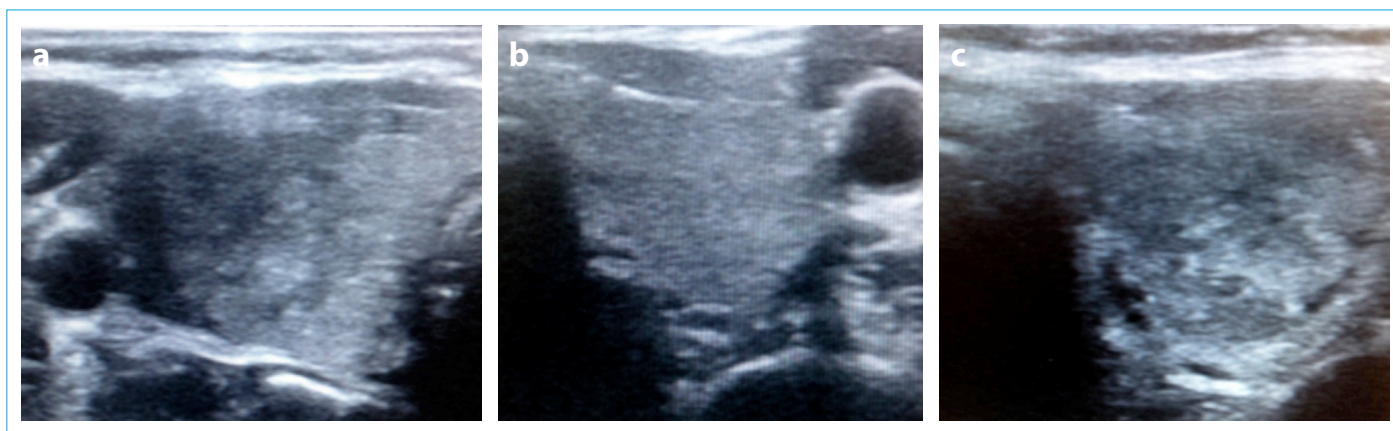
(a-c). (a) Transverse grayscale sonogram showing poorly defined patchy hypoechoic lesions in the right thyroid lobe (at admission). (b) Transverse grayscale sonogram showing normal thyroid parenchyma in the left thyroid lobe (at admission). (c) Transverse grayscale sonogram showing poorly defined patchy hypoechoic lesions in the left thyroid lobe (16 days after admission).
